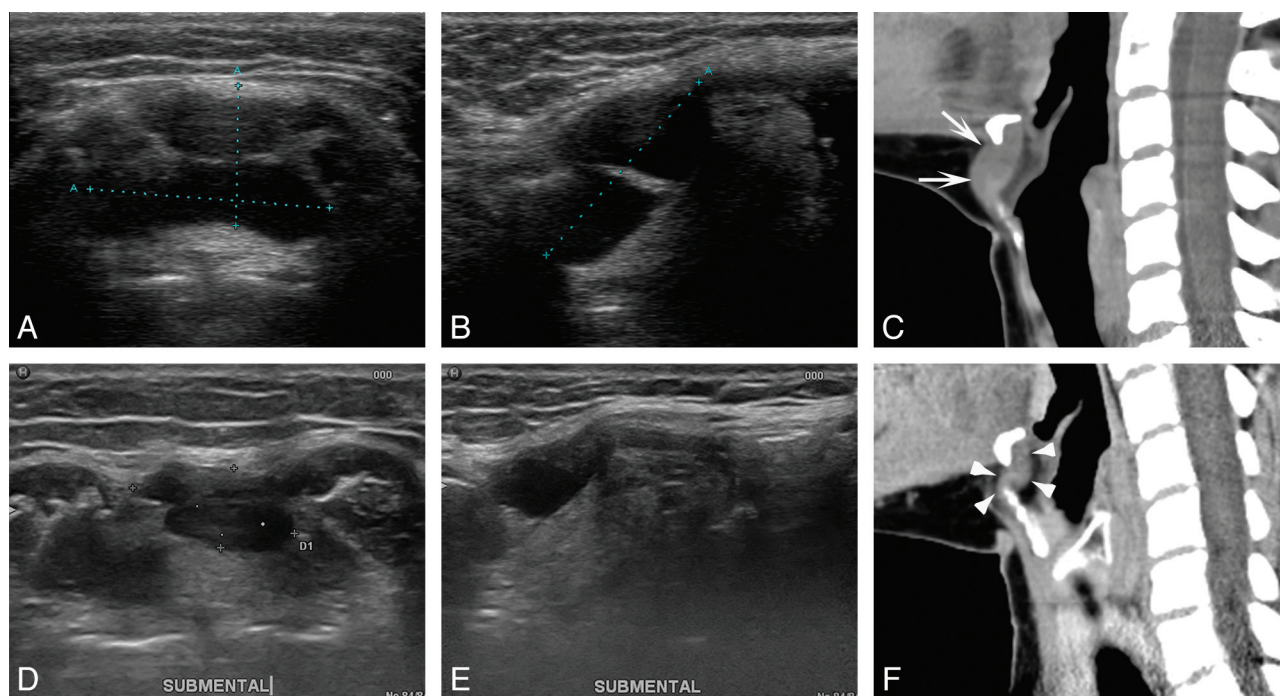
A 39-year-old woman (patient 11). Axial (A) and longitudinal (B) sonograms show a multiloculated TGDC in an infrahyoid location ($1.2 \times 2.0 \times 2.2$; volume, 2.76 mL). Sagittal CT scan (C) shows that the TGDC wraps around the hyoid bone (arrows). Axial (D) and longitudinal (E) sonograms and a sagittal CT scan (F) obtained 11 months after EA. Arrowheads indicate shrinkage of the TGDC ($0.66 \times 0.85 \times 1.18$; volume, 0.35 mL; volume reduction, 87.5%).
